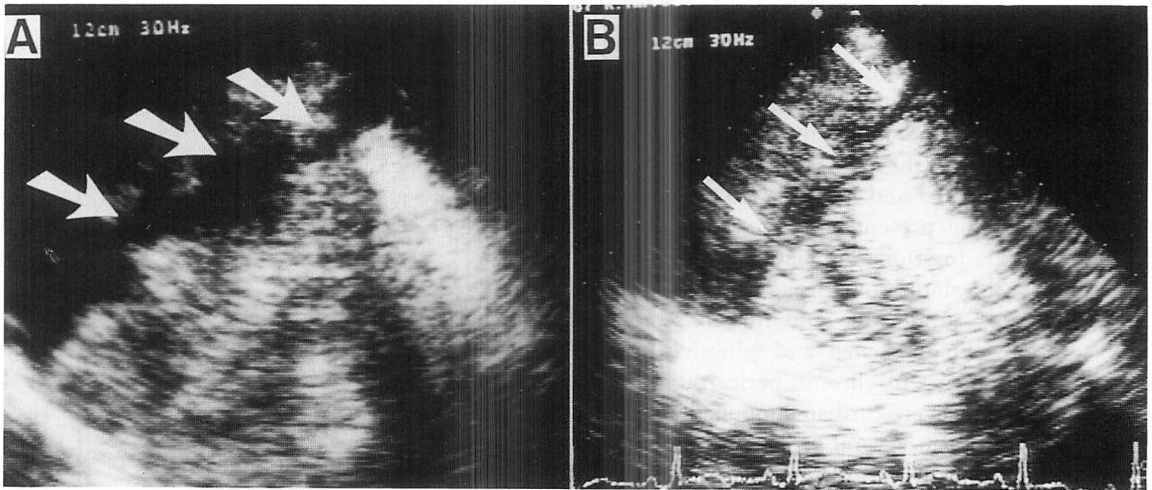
The change in the penetrating wound during the follow-up study by two-dimensional echocardiography.
